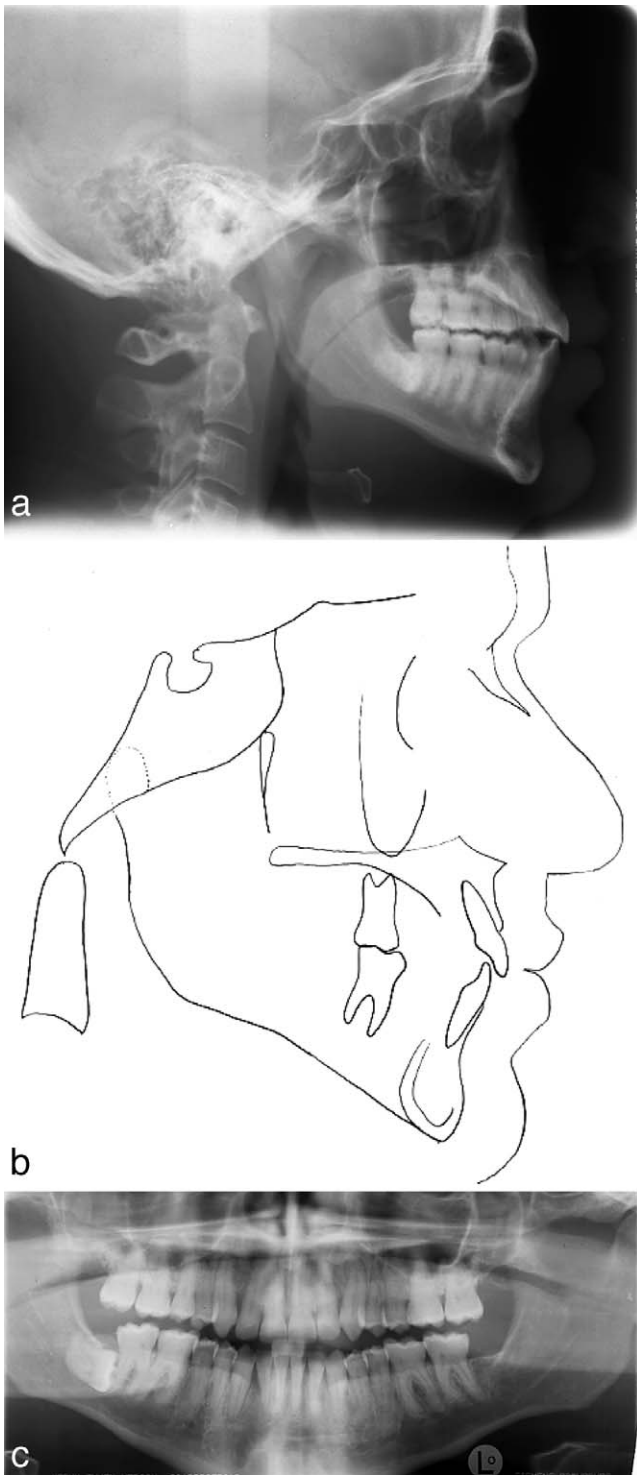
Post treatment radiographs and post treatment lateral cephalometric tracing.
